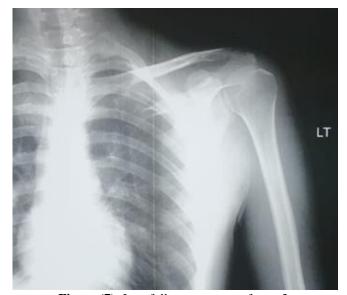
Last follow up x-rays of case 3.
